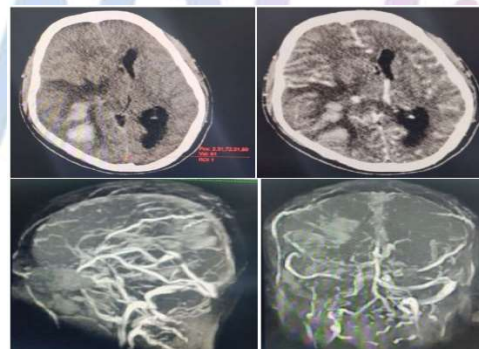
40years male patient presented with altered sensorium and left hemiparesis A: Axial plain CT shows hemorrhagic infarct in right temporo-parietal region with midline shift to left; B: Axial contrast CT shows non opacification of right cortical veins and empty delta sign of superior sagittal sinus; C and D: MR Venography shows occlusion of superior sagittal sinus, right transverse and sigmoid sinus and right superficial cerebral veins
